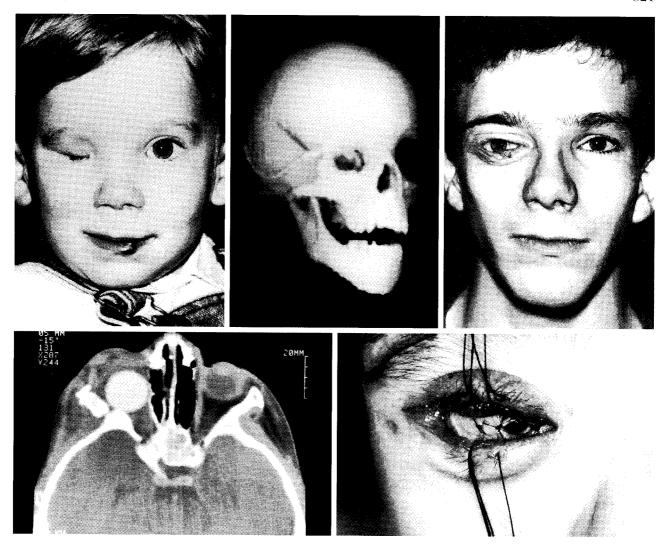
Examples of an initial attempted orbital expansion using a sperical tissue expander. In this case, the reconstruction was set back after rupture of the expander, and a further orbital expansion by ostcotomy was required. (*Above, left*) Male patient aged 2 years, with right microphthalmos, before evisceration and placement of a sperical silicone expander in the orbit. (*Above, center*) Three-dimensional computed tomography reconstruction showing the expander in place (patient aged 3 years). (*Above, right*) The patient at 16 years, after having also undergone a medial and lateral canthopexy, lower cyclid reconstruction with an upper lid flap, upper lid reconstruction with a full-thickness skin graft, correction of ptosis, and fitting of an ocular prosthesis. (*Below, left*) Rupture of the expander occurred within 6 months of its placement. A severe contraction within the orbit ensued, which necessitated orbital osteotomics, transposition of the temporalis muscle, and the placement of a silicone implant within the orbit (shown here on an axial computed tomography scan taken when the patient was 5 years old). (*Below, right*) Reconstruction of the conjunctival sac using buccal mucosal graft sutured over a conformer (patient aged 6 years).
